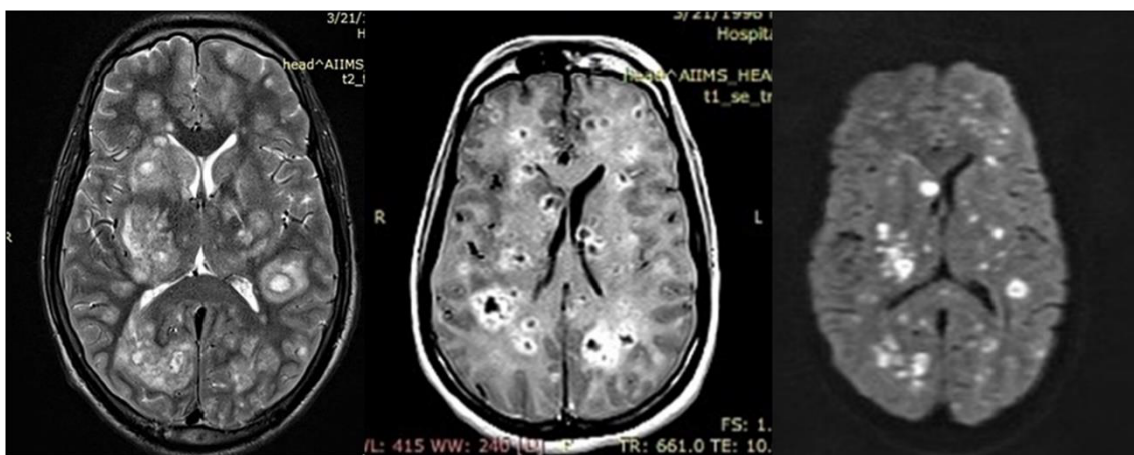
Magnetic resonance imaging (MRI) T2, T1 and diffusion restriction sequence showing multiple infarcts (septic emboli).
